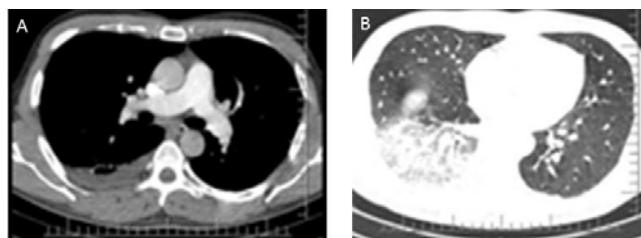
Computed tomography angiography of the chest revealed right sided pleural effusion (A) and pneumonic consolidation (B).
